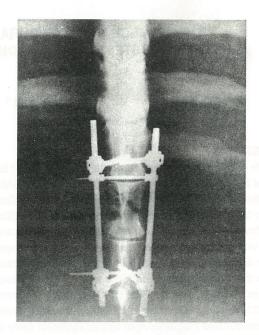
Radiograph showing burst fracture of the lumbar first vertebra stabilized with anterior ASS.
